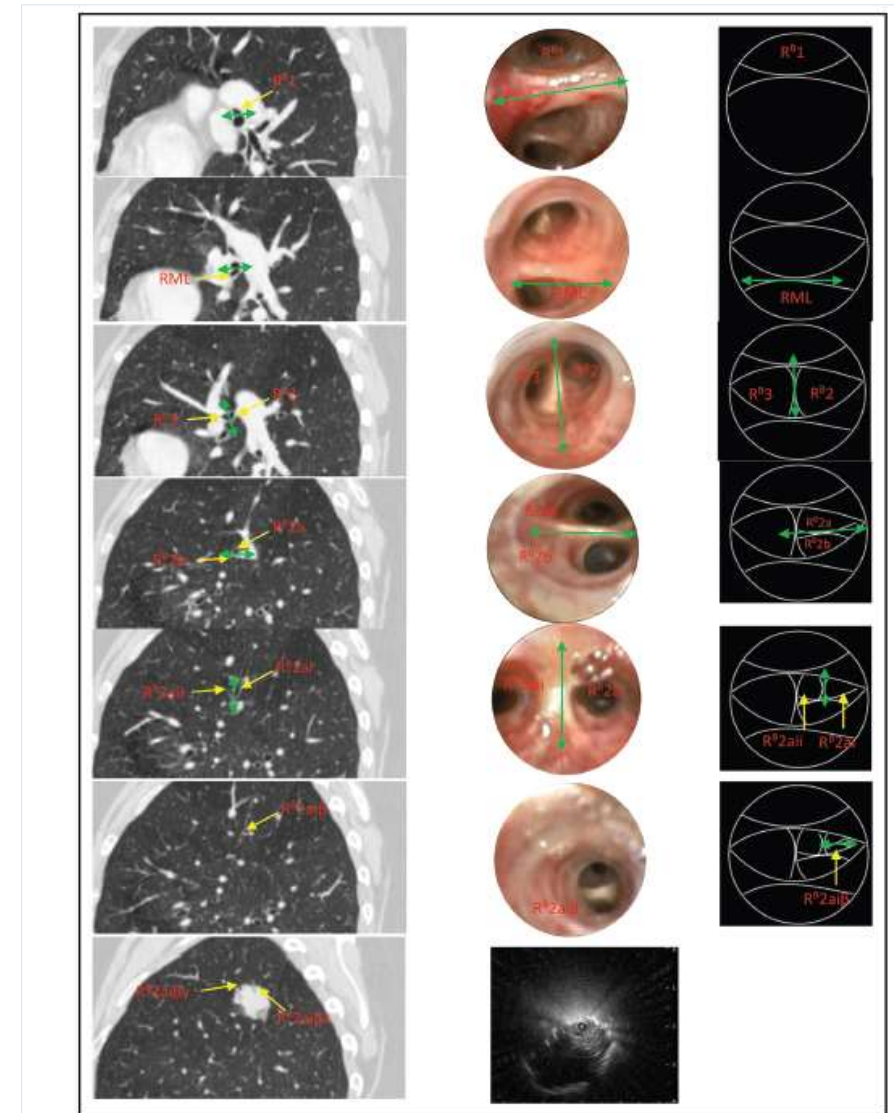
Case example of airway mapping. A PPL located in the posterior segment of the right upper lobe (R²a) is traced using the sagittal multiplanar reconstruction of the CT scan. The bronchial segments are mapped out based on the CT scan, and a r-EBUS probe inserted into R²a_{ij} (bronchoscopic image not available) confirms localization of the PPL. Fluoroscopy was utilized for biopsy and rapid on-site evaluation touch imprint demonstrated the presence of malignant cells.
